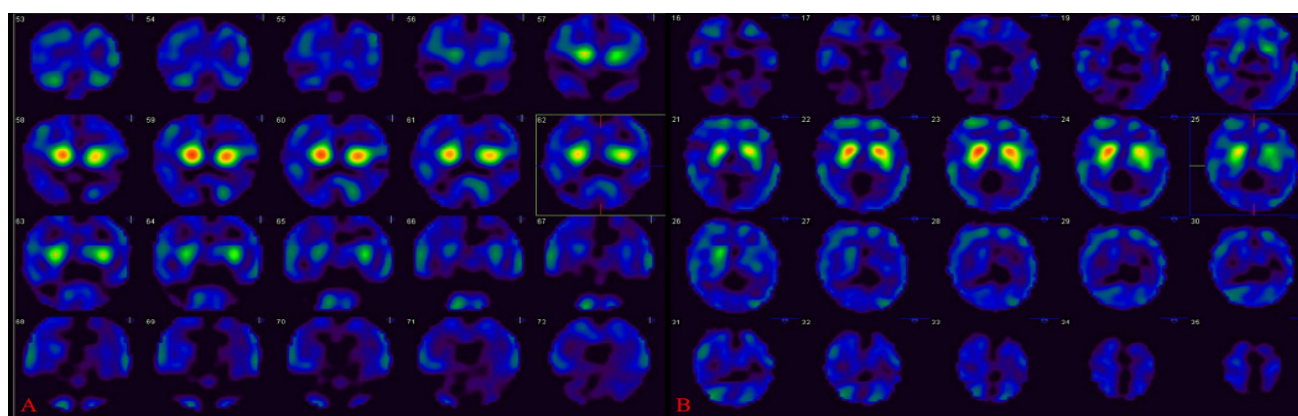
Tc-99m TRODAT-1 SPECT images revealing normal uptake in the bilateral basal ganglia (A. coronal; B. transverse)
